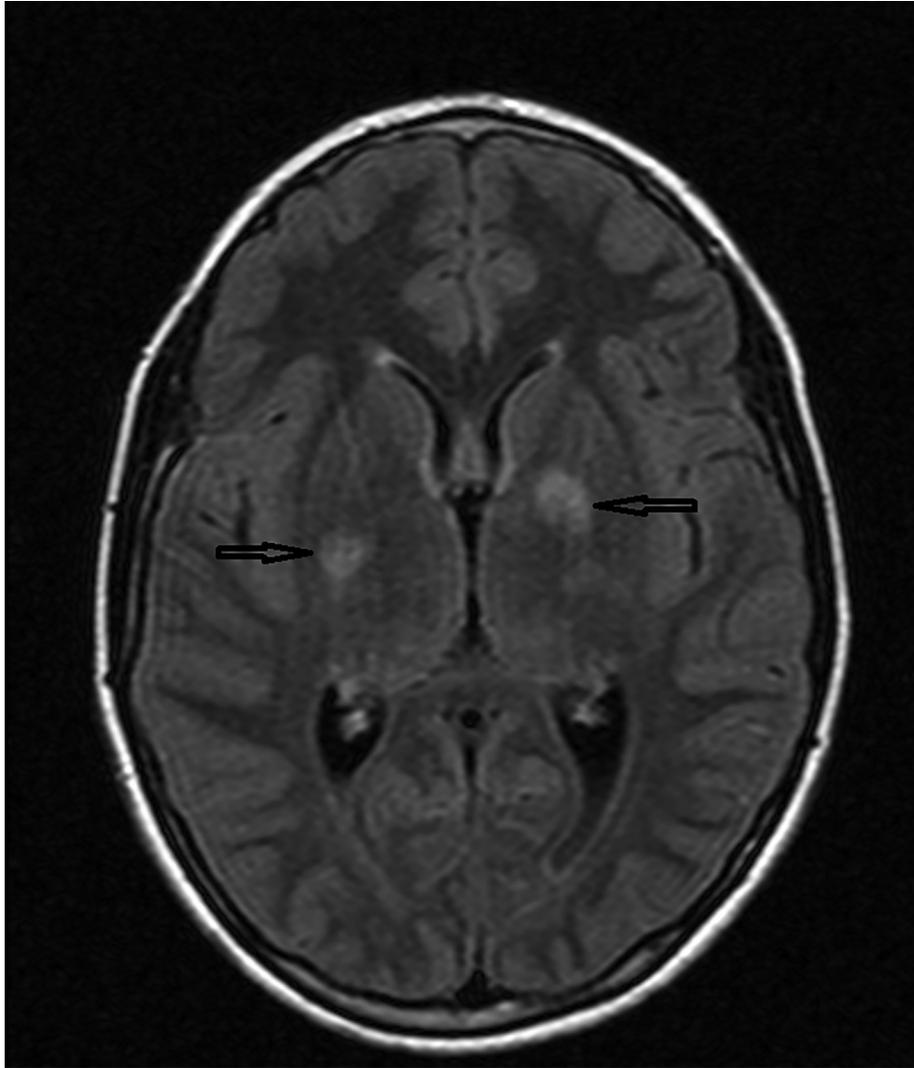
FLAIR in axial plane, 11 yr. Boy with NF1, FASI involve basal ganglia (black arrows).
